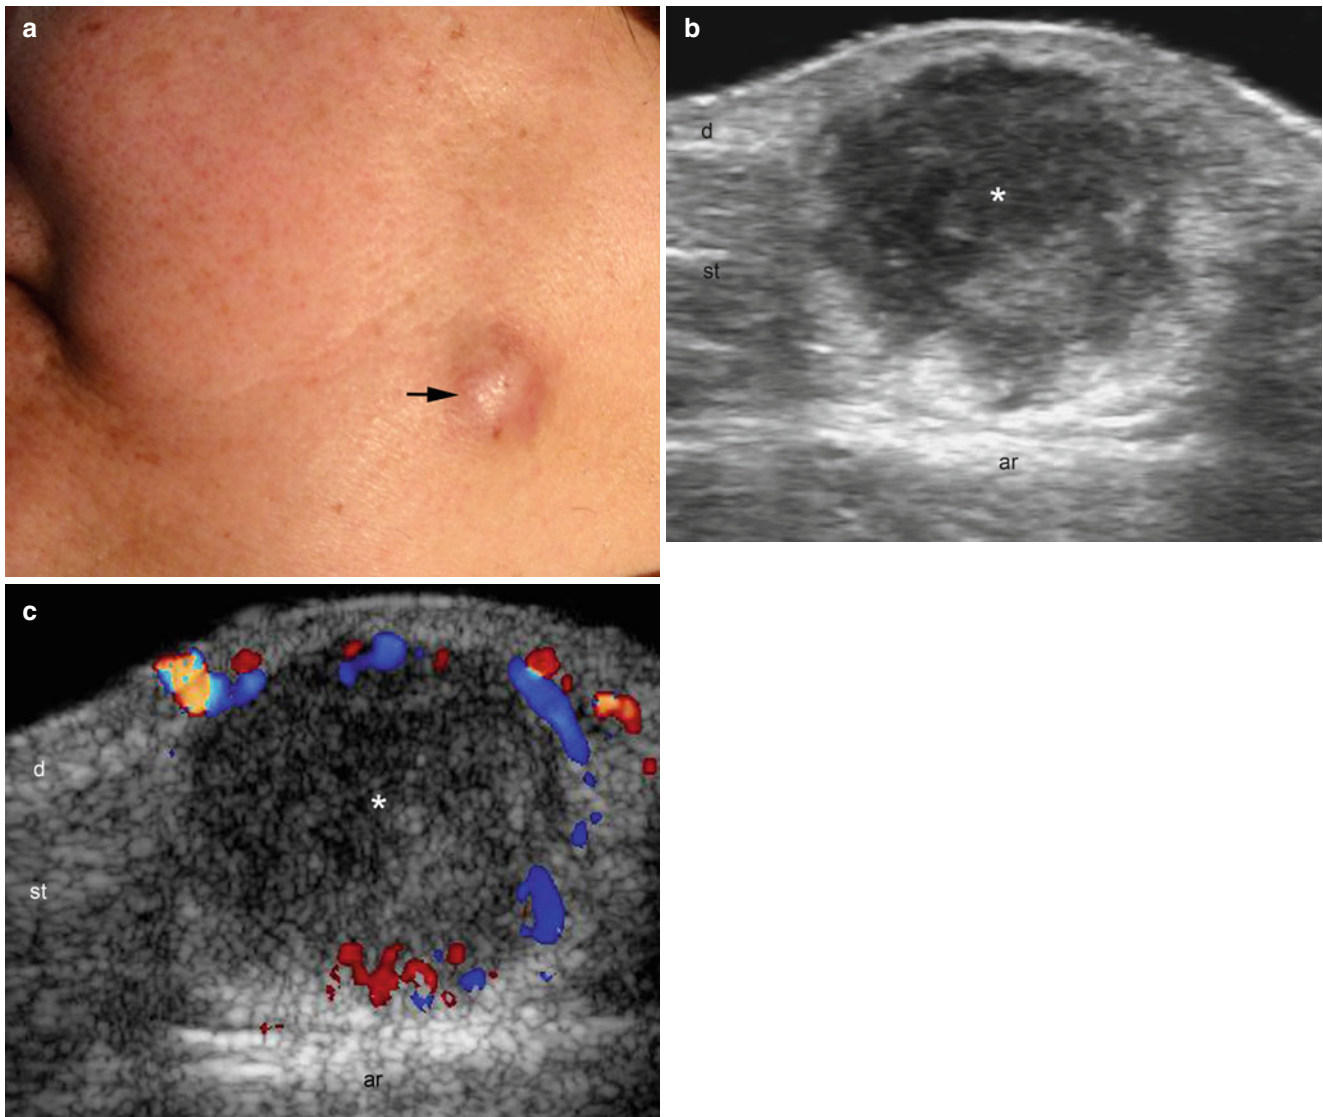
(a–c) Epidermal cyst with total rupture. (a) Clinical lesion shows erythematous swelling (*arrow*) in the left aspect of the cheek. (b) Grey scale ultrasound image (transverse view) shows hypoechoic structure (*) with irregular borders located in the dermis and subcutaneous
